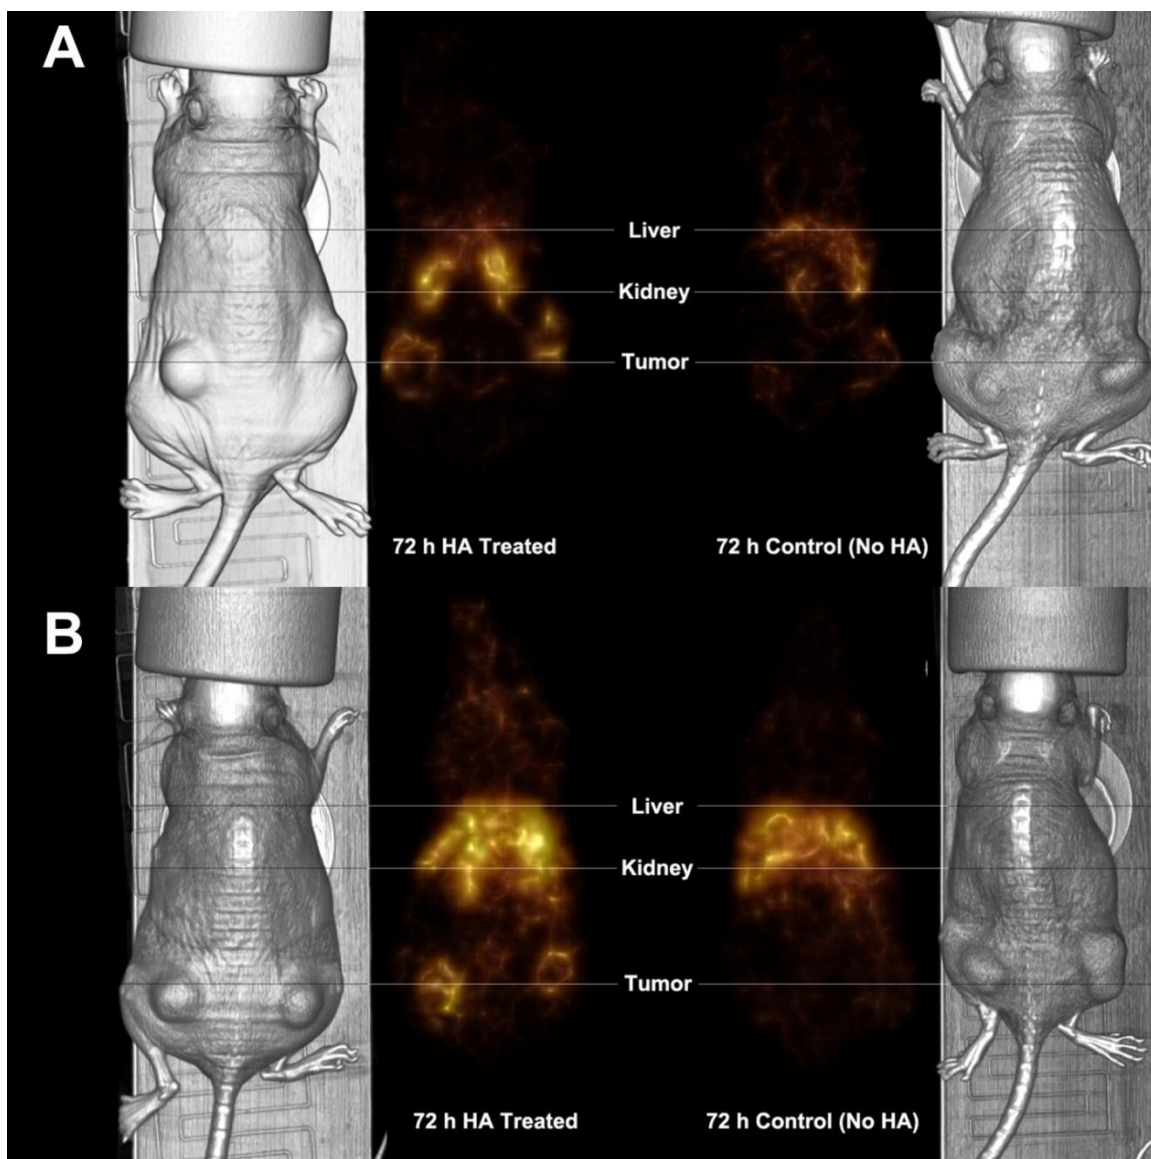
SPECT/CT images comparing hyaluronidase effects. SPECT images demonstrating the increase in tumor accumulation after treating with hyaluronidase. A) Comparison of tumor localization based on KCCYSL or HER2 targeting conjugate at 72 h postinjection. B) Comparison of tumor localization based on RGDfK or $\alpha_v\beta_3$ integrin targeting conjugates at 72 h postinjection.
